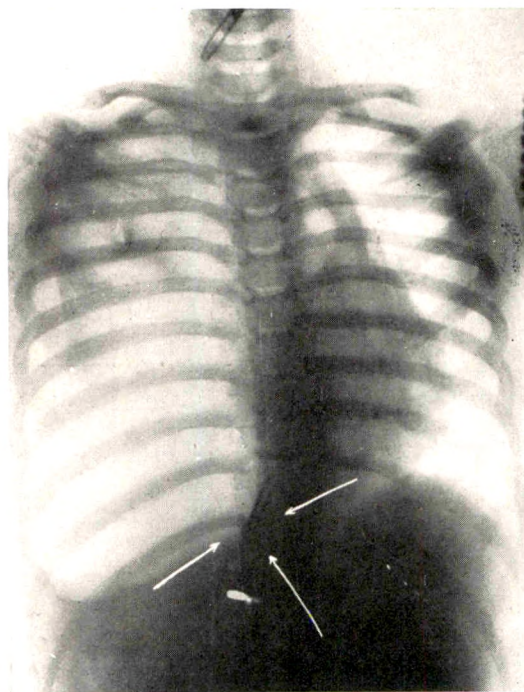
A staple is in a completely compressed left lower lobe. There is also an extensive pyopneumothorax. The staple was removed surgically through an opening in the chest wall. The surgeon's forceps were directed into the collapsed lung by means of the double plane roentgenoscope.
